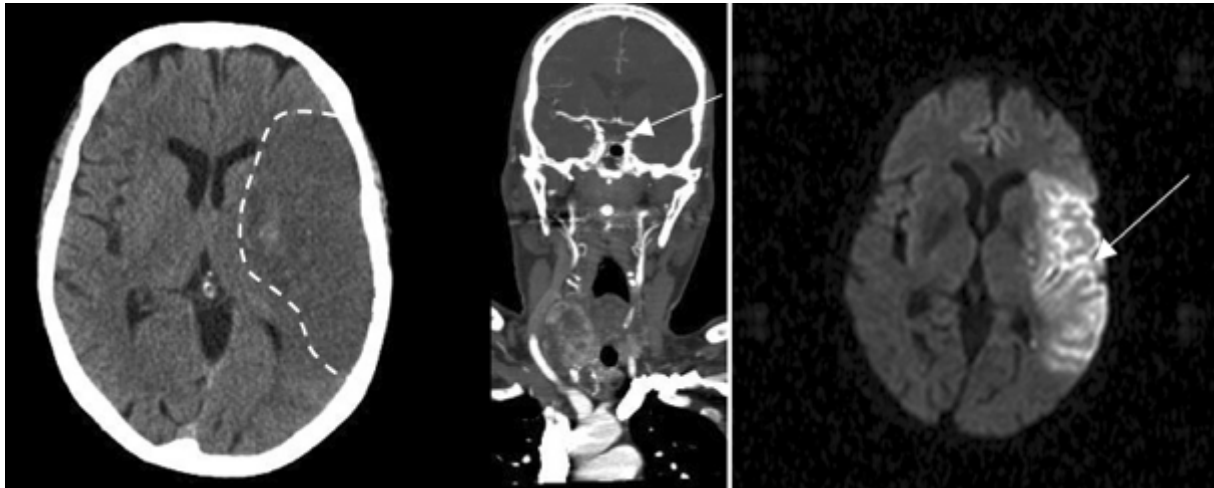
Example of a cerebral infarction on the left hemisphere due to a M1 thrombosis of the middle cerebral artery: computed tomography (CT) scan with a demarcation zone (left side), CT-angiography which shows a stop of flow (see arrow in the middle), DW-MRI (diffusion weighted-magnetic resonance imaging) which shows the extend of edema caused in the zone of tissue infarction (courtesy Department of Neuroradiology, Medical University of Vienna).
